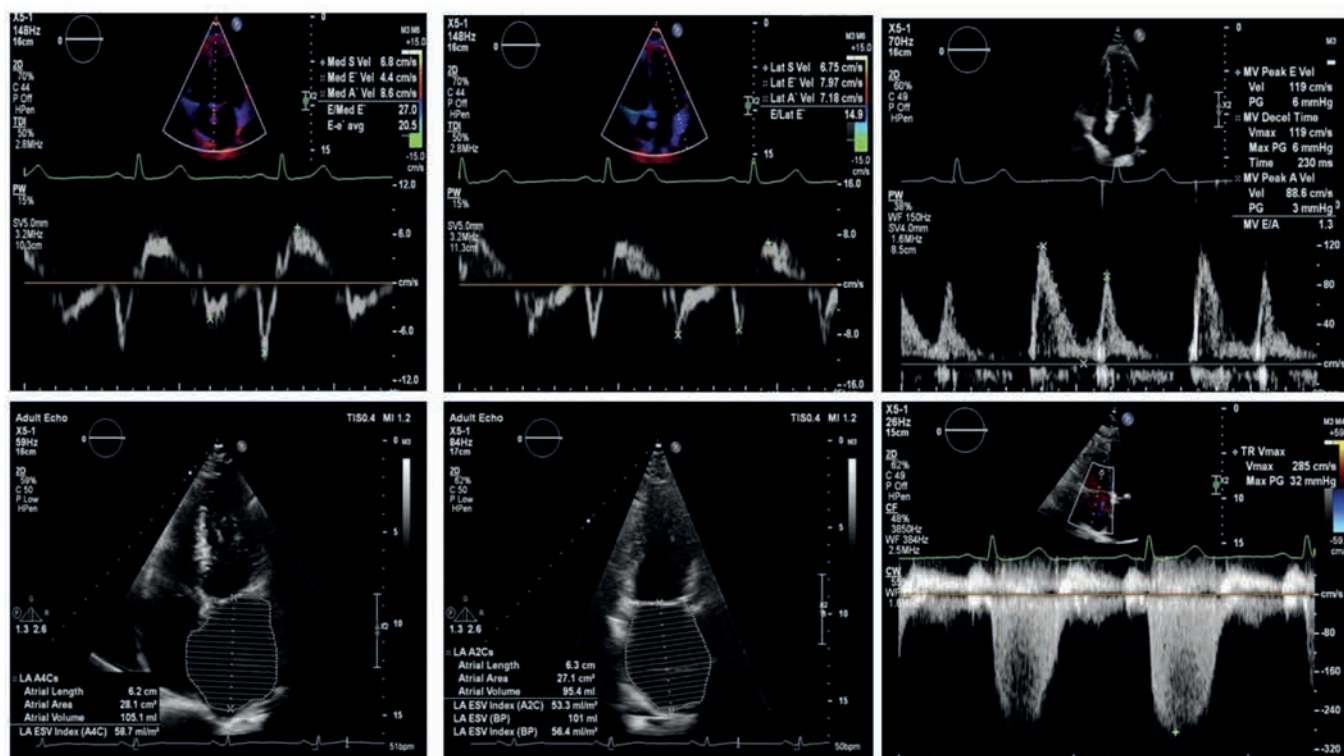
Typical echocardiographic features suggestive of HFpEF. From left to right: abnormal septal E', lateral E', MV deceleration time, dilated left atrium and elevated pulmonary pressures suggestive by TR Vmax.
